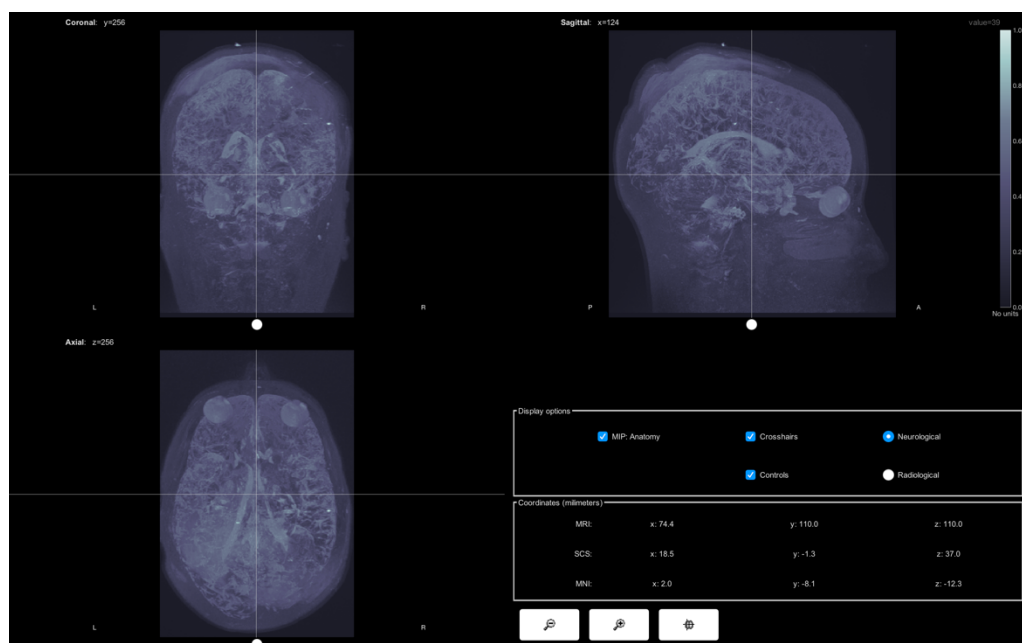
Magnetic resonance imaging (MRI) from the patient after the implantation of intracranial electrodes.
